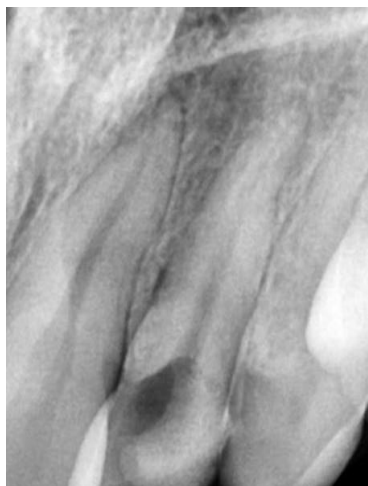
Preoperative periapical radiograph of the maxillary left lateral incisor
